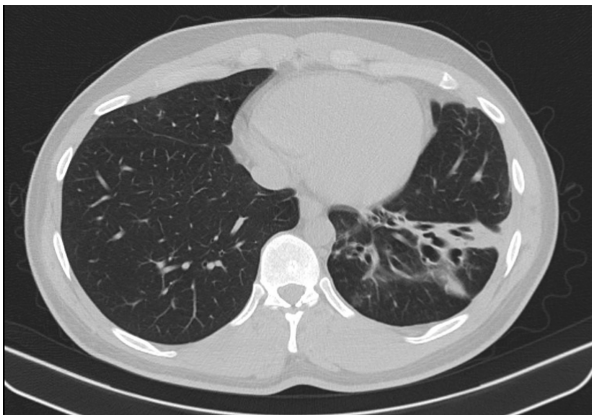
Residual localized bronchiectasis on follow up computed tomography thorax.
